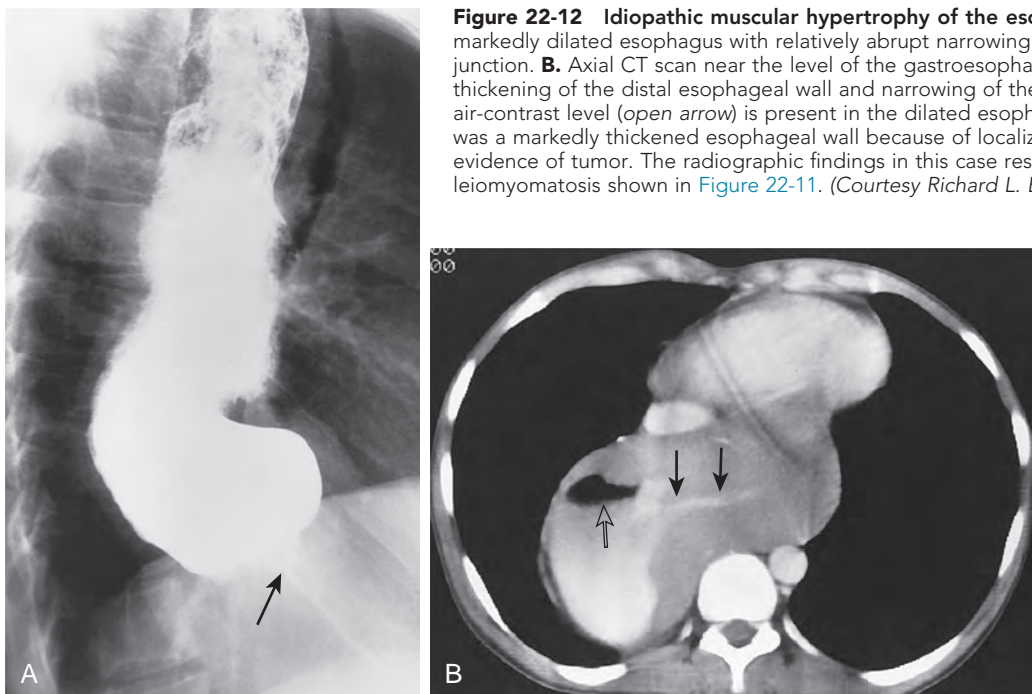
Idiopathic muscular hypertrophy of the esophagus. A. Barium study reveals a markedly dilated esophagus with relatively abrupt narrowing (arrow) near the gastroesophageal junction. B. Axial CT scan near the level of the gastroesophageal junction shows massive thickening of the distal esophageal wall and narrowing of the lumen (closed arrows). An air-contrast level (open arrow) is present in the dilated esophagus to the right. At surgery, there was a markedly thickened esophageal wall because of localized muscular hypertrophy without evidence of tumor. The radiographic findings in this case resemble those of esophageal leiomyomatosis shown in Figure 22-11. (Courtesy Richard L. Baron, MD, Pittsburgh, PA.)
